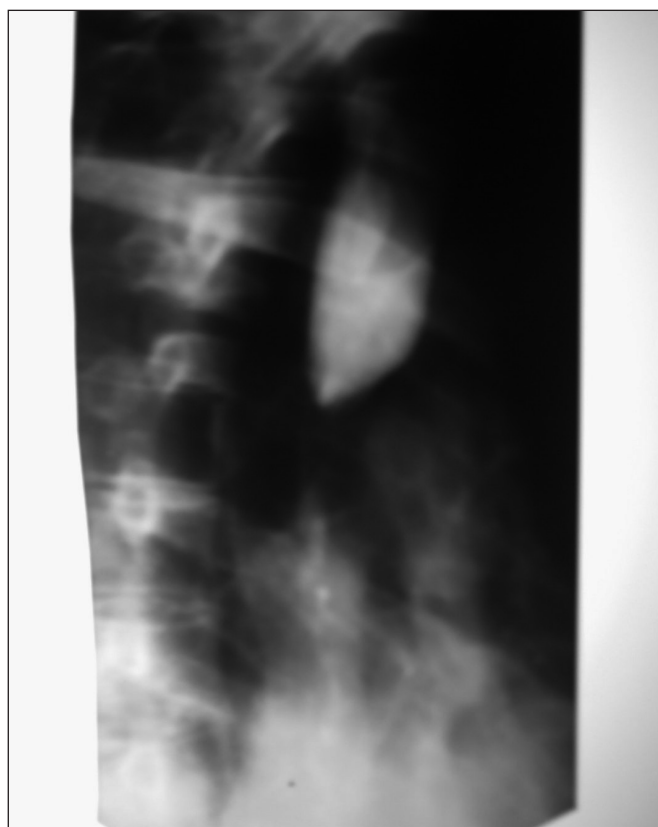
X-ray examination of the upper part of GIT
